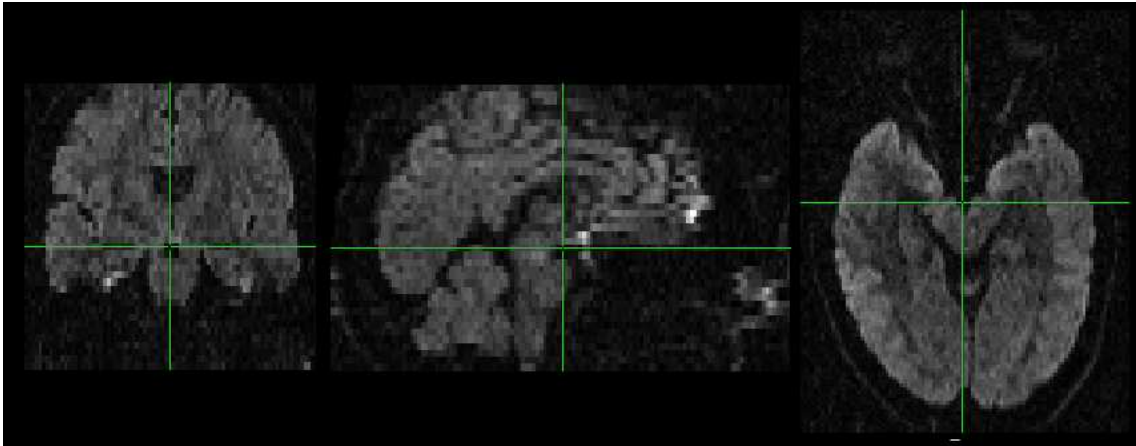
Three slices of DW-MRI data in a given gradient direction. (left) coronal view, (middle) sagittal view and (right) axial view of the human head.
